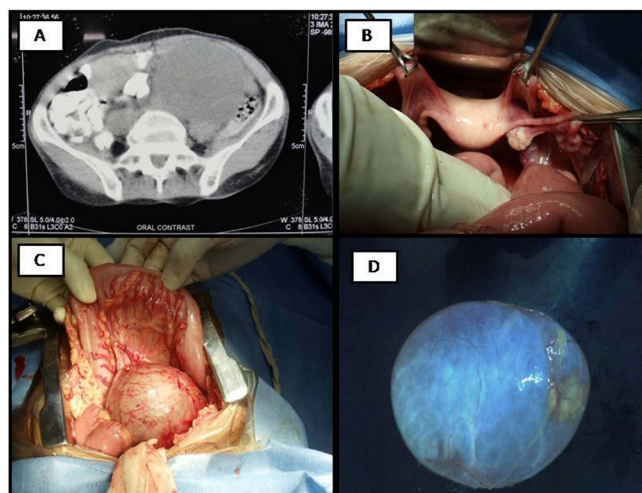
(A) CT image showing retroperitoneal soft tissue oval mass, seen in left lumbar region extending into left adnexal region. (B) Intraoperative image showing both the ovaries and fallopian tubes free of cyst wall. (C) Intraoperative image of the cyst. (D) Gross image of the excised cyst.
